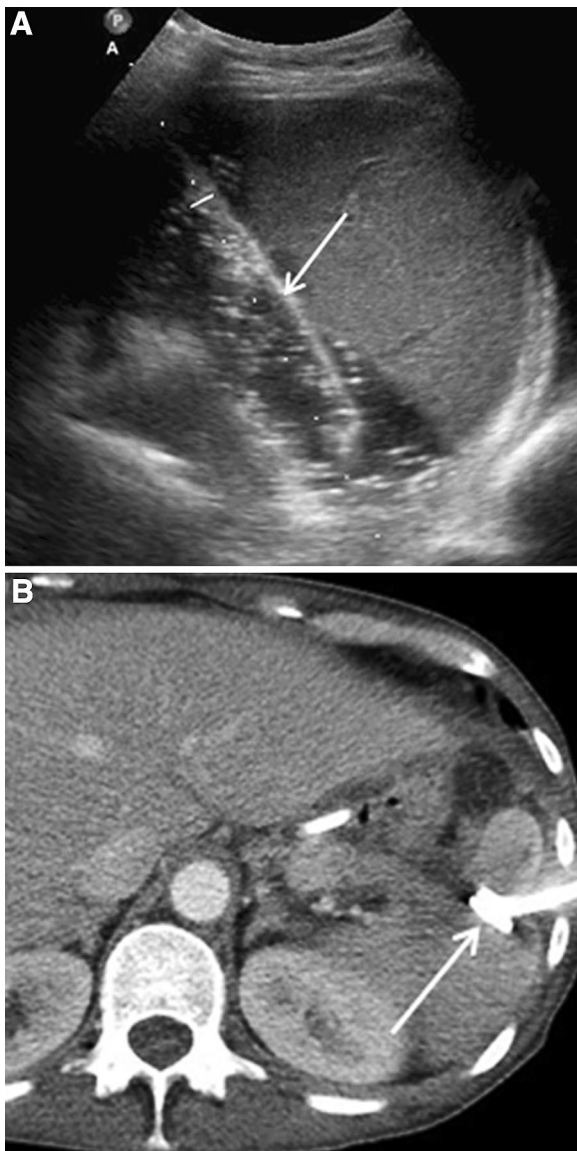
Ultrasound-guided splenic abscess drainage. 65-year-old woman with fever and abdominal pain, same patient as Fig. 6. A Ultrasound image during percutaneous drain placement. The echogenic, linear structure (arrow) is the needle passing into the abscess cavity. The drain was subsequently placed via the trocar technique, and is seen on follow-up CT imaging (B, arrow).
